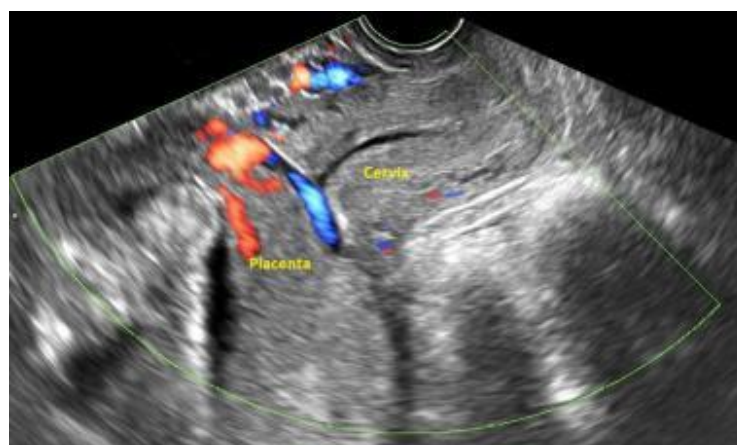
Complete placenta previa noted on ultrasound[3].
